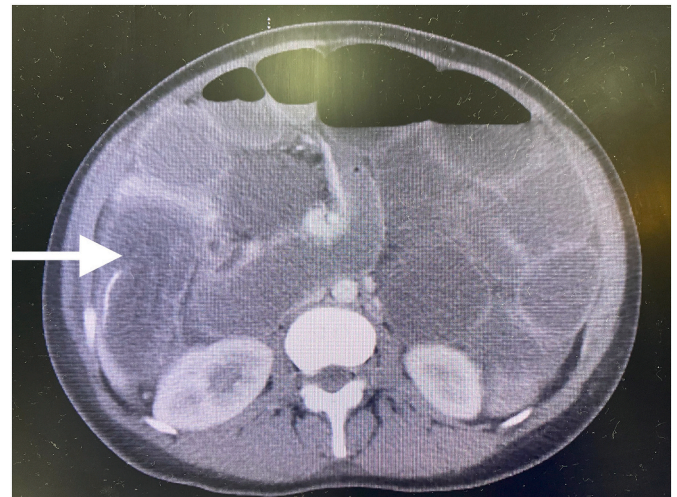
Axial slice CT scan of the abdomen showing the intussusception which is at the level of small bowel anastomosis suture.
